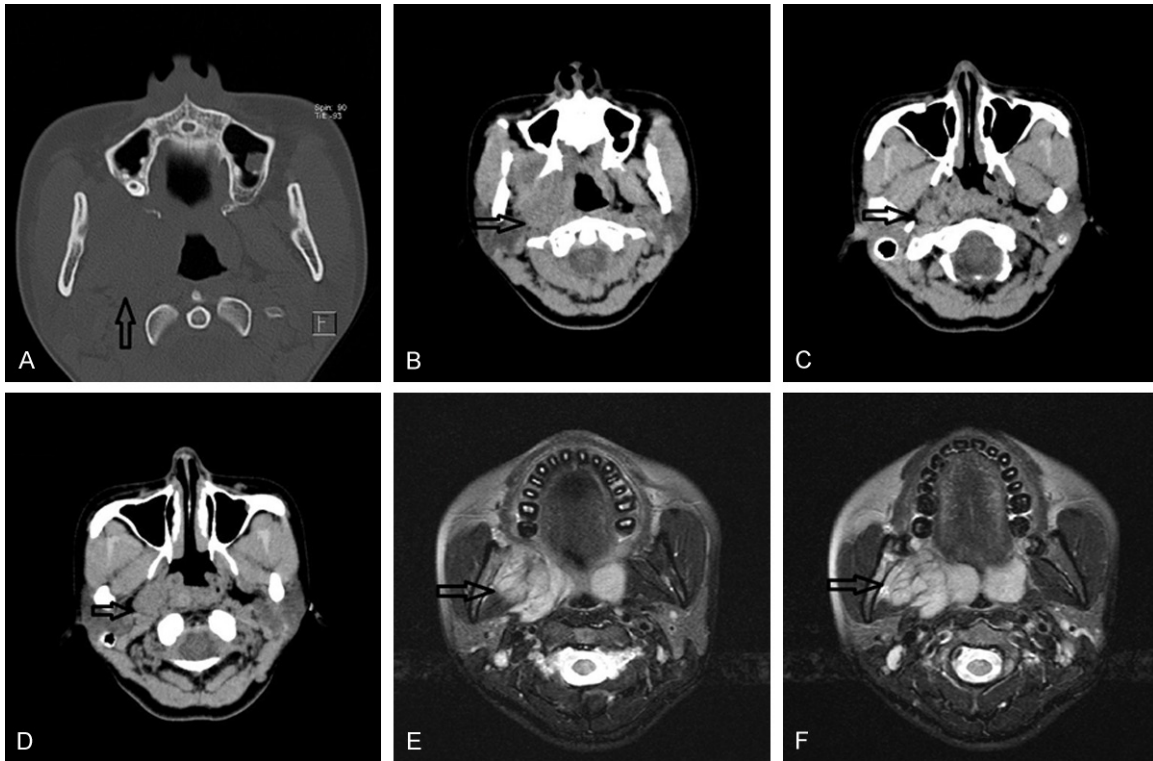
Imaging of the tumor. The CT detected the lesion but the border is not clear. We can know only an approximate location of the mass from the image (black arrow) (A). The enhancement CT detected the mass (black arrow) more clearly (B-D). The tumor was most clearly found in the MRI imaging (black arrow) (E, F).
